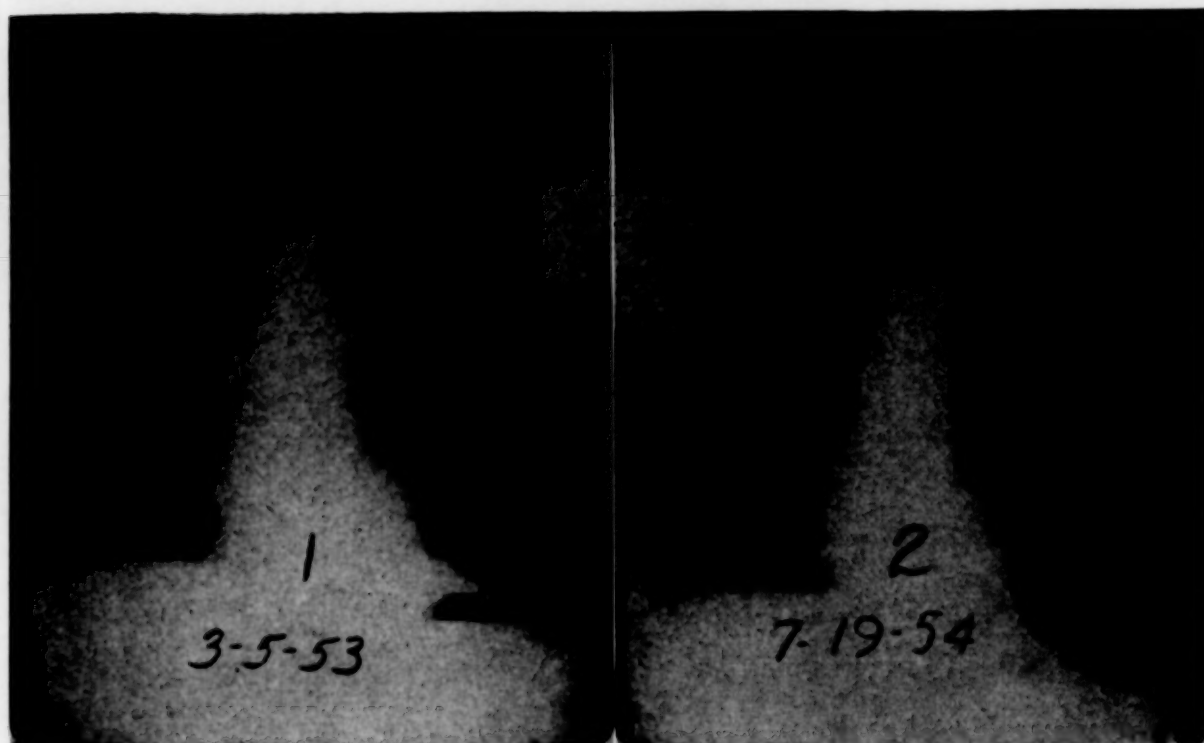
CASE VI. Preoperative roentgenograms showing increase in size of bullae in left lung. Note compression of lung in hilar region.
